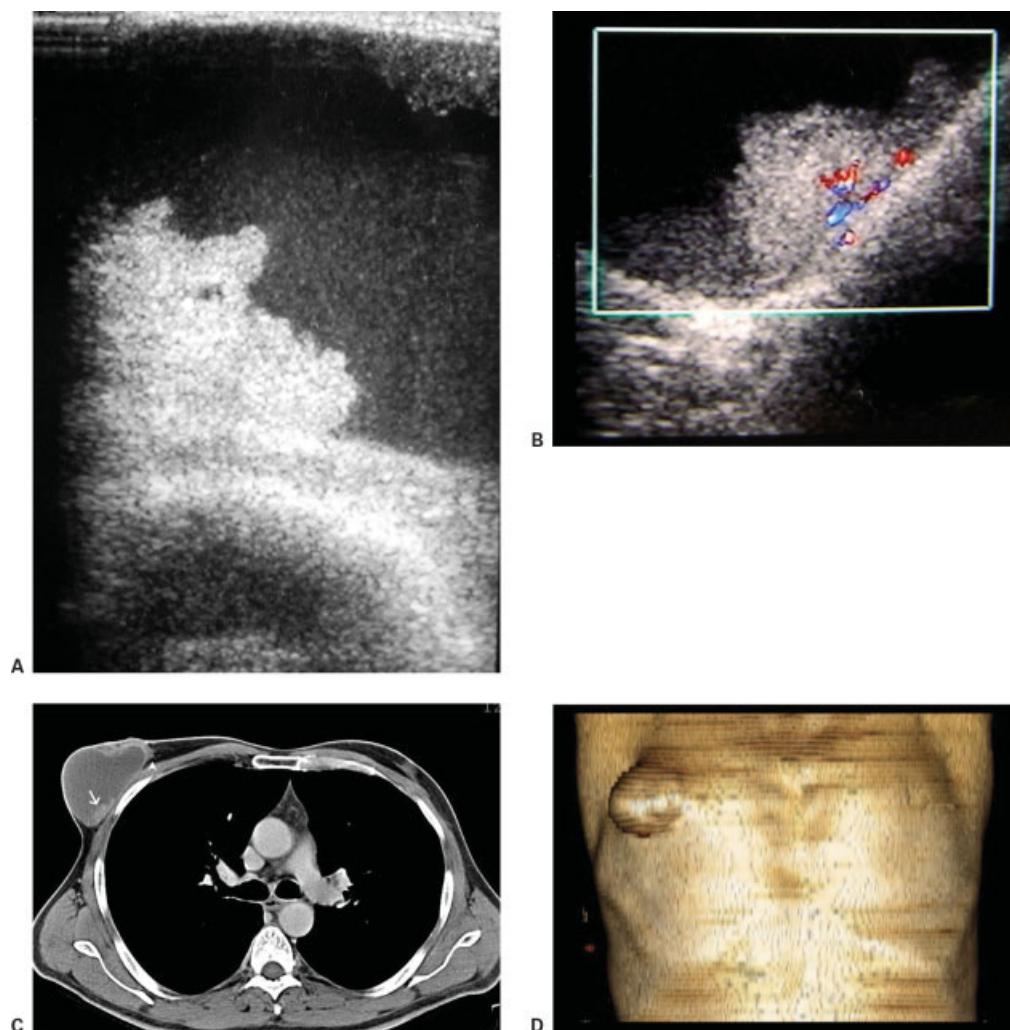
A 51-year-old man with biopsy-proven infiltrating ductal carcinoma. (A) Sonogram shows a predominantly cystic mass with solid mural projections in the anterior and posterior of the cyst wall and intraluminal debris. (B) Color Doppler sonogram shows significant blood flow in the intraluminal solid component. (C) CT scan shows the mass with multiple, enhancing intraluminal mural nodules (arrow), some of which infiltrate the subcutaneous fat of the anterior thoracic wall (arrowhead). (D) Volume rendering CT image shows the mass in the right upper outer quadrant.
